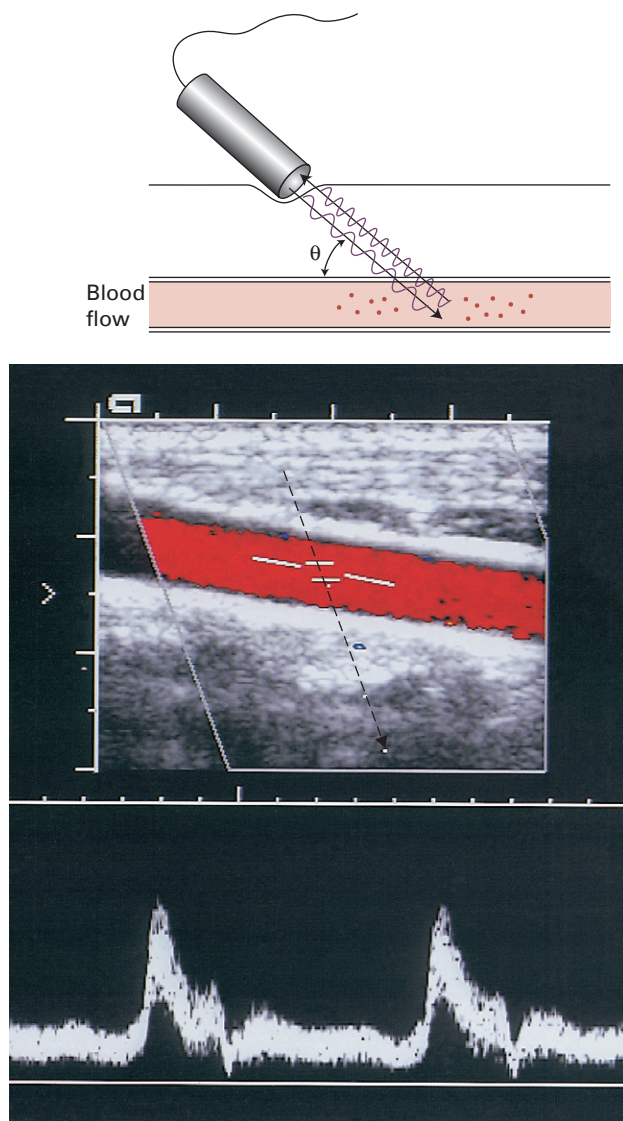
Principle of Doppler ultrasound. In this example, flowing blood is detected in a normal carotid artery in the neck. With blood flowing away from the transducer, the frequency of the received sound is reduced, whereas with blood flowing towards the transducer, the frequency of the received sound is increased. For anatomical images, the flowing blood is colour coded according to the direction of flow. (θ is the angle between the vessel and the transmitted sound wave: an angle known as the Doppler angle. The angle of the beam is indicated by the fine zig-zag line across the image.) The flow-velocity waveform has been taken from the gate within the artery. The peaks represent systolic blood flow.
